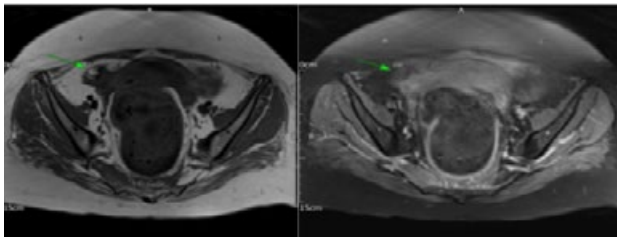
Axial T1 (1a) and axial T1 fat-saturated post gadolinium (1b) MRI images of the pelvis demonstrated a 2cm right adnexal lesion (arrows) which demonstrates high signal on the T1 image and signal suppression on the T1 fat saturated image, confirming macroscopic fat contents consistent with a right ovarian dermoid.
